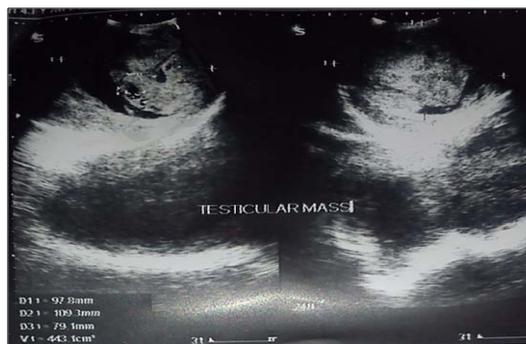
Ultrasound of scrotum showing testicular mass
